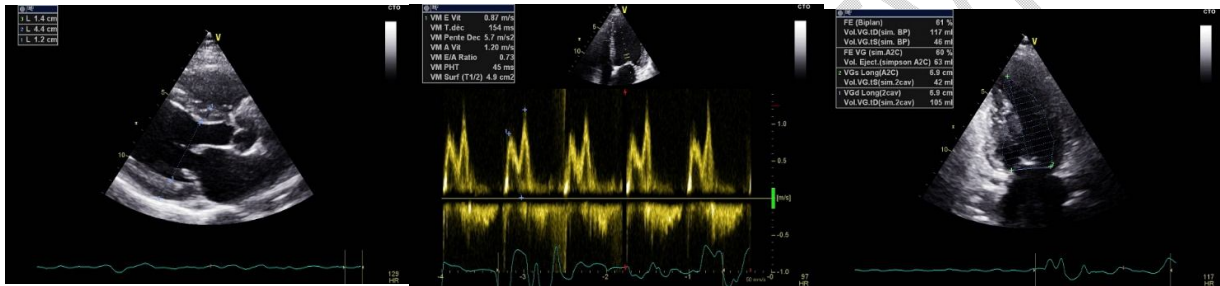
Transthoracic Echocardiography images showing hypertensive heart disease with good ventricular function
